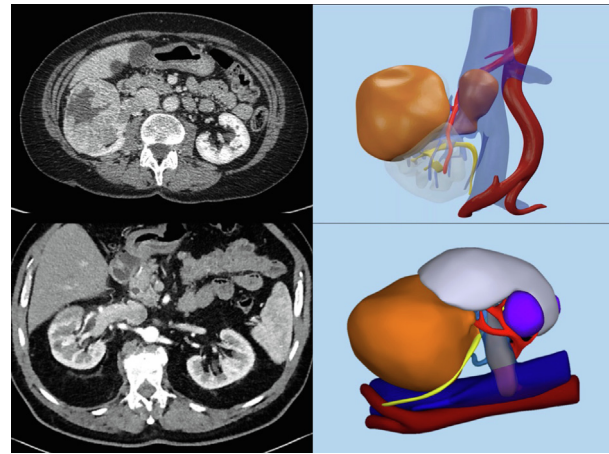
Hyperaccuracy three-dimensional models were generated from preoperative computed tomography scans.
